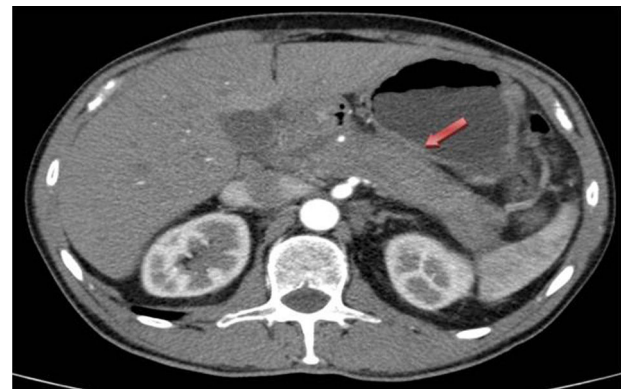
CT image showing the pancreatic gland that is increased in size.
